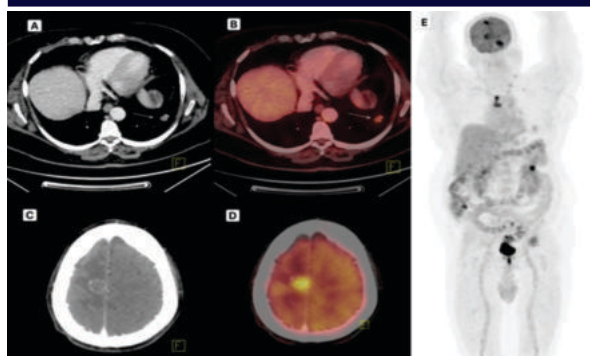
55-year-old man with EGFR mutated stage IV lung Adenocarcinoma. CT and PET images show a 2.0 x 1.6 cm lesion in lower lobe of left lung (A, B) with pSUVmax = 5.6, metastatic lesion in brain (C, D) with high mSUVmax = 19.3. E is MIP image
